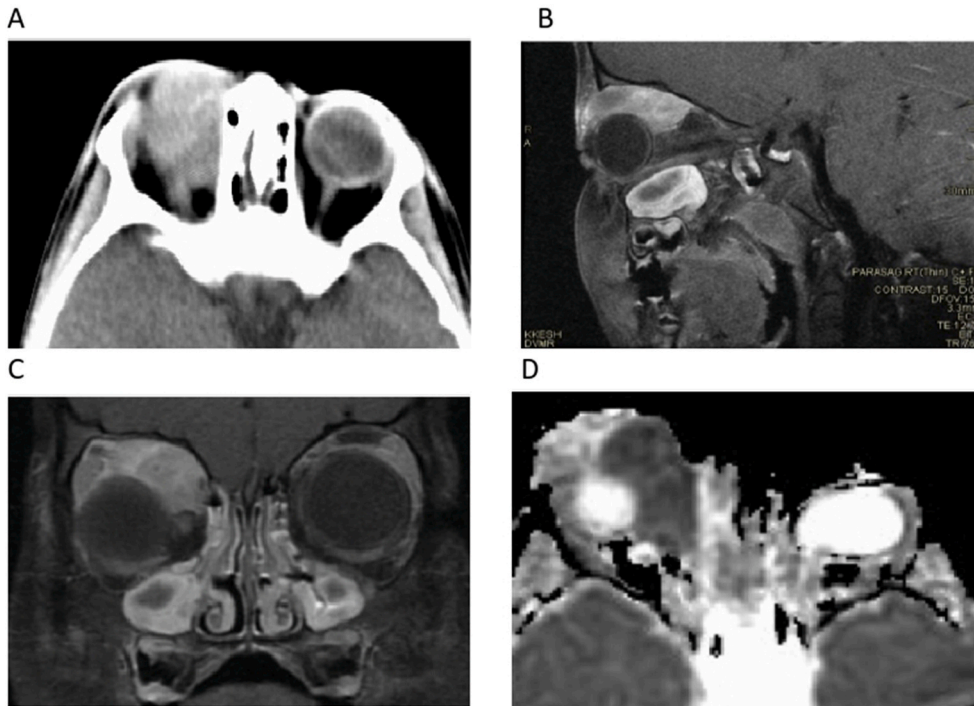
Axial CT scan orbit (a) and sagittal T1 fat suppressed post contrast (b,c) and axial DWI (D) images showing solid lobulated extra-conal orbital lesion arising superiorly along the orbital roof and nasal infiltrating the recti muscles and superior oblique muscle. The lesion presents marked restricted water diffusion on DWI (c) indicating high degree of cellularity. The lesion abutting the lacrimal gland with no definite line of separation.
